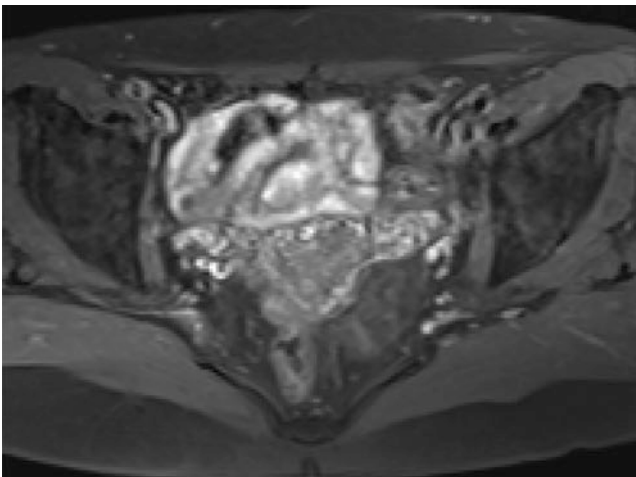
T1-weighted contrast-enhanced image showed the mass was slightly enhanced
